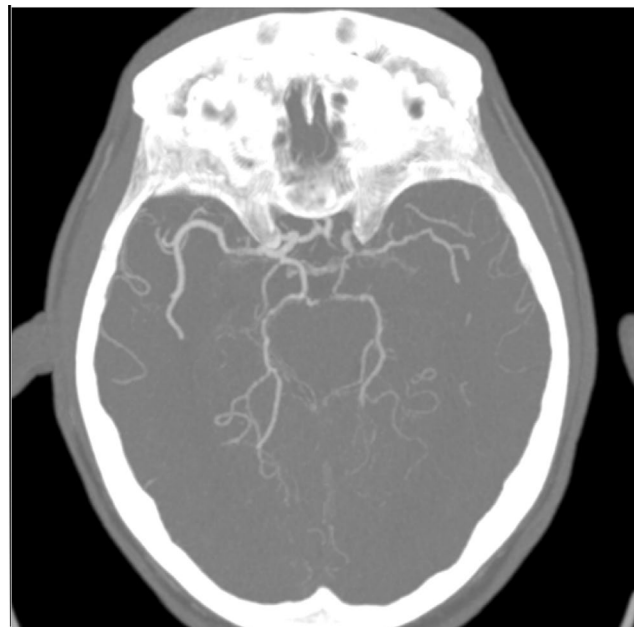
CT angiography showed multifocal intracranial arterial narrowing and beading, involving both the anterior and posterior circulation.
